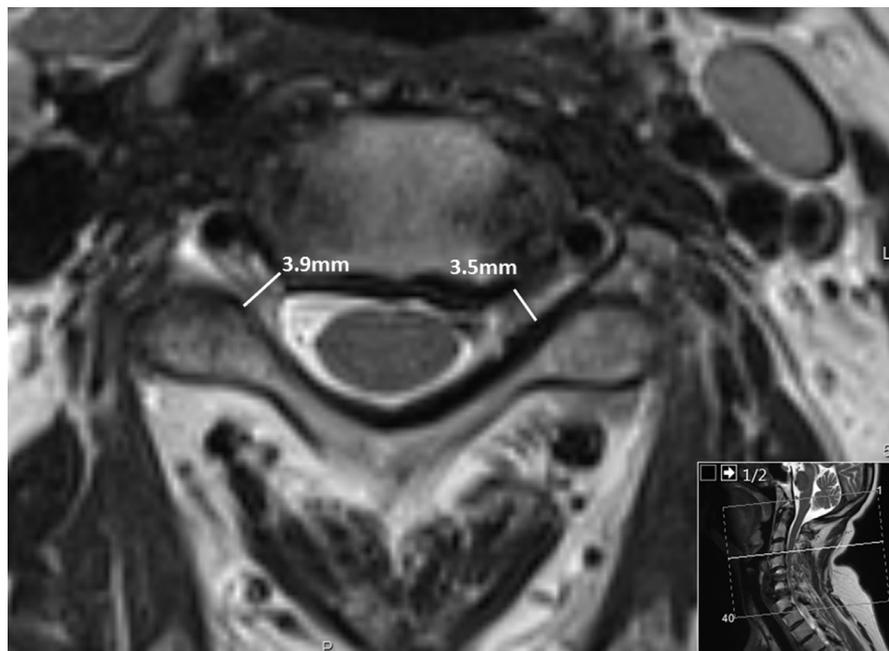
SDI measurement (foraminal stenosis), T2-weighted axial image with bilateral foraminal stenosis (1 point).
